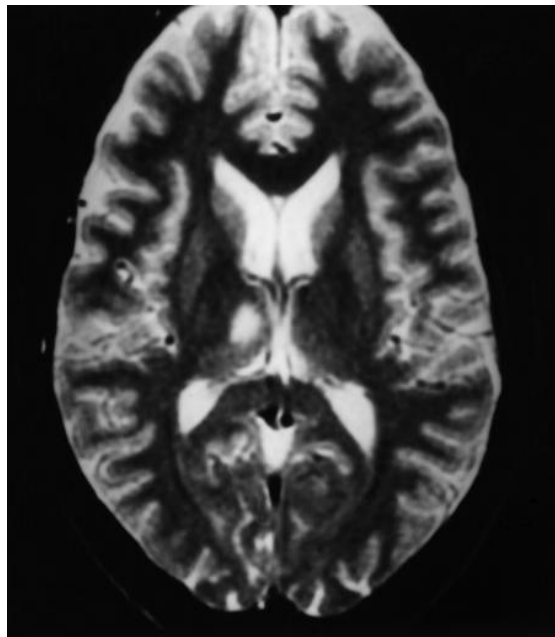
T2-weighted MRI scan showing unilateral right paramedian infarction.
